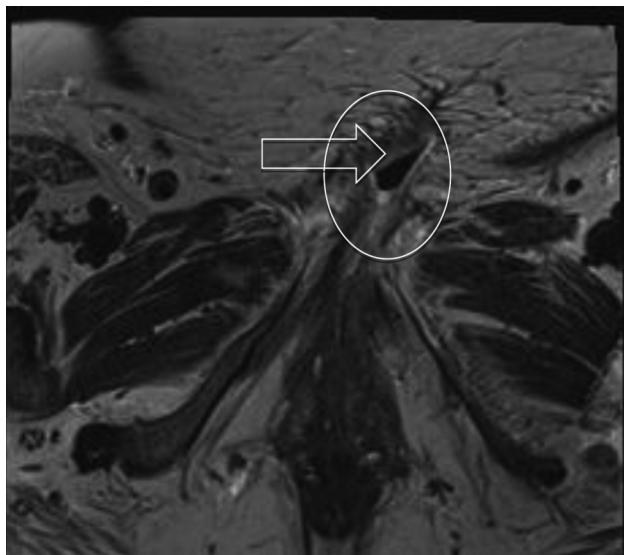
Axial T2-weighted image 18 months after surgery
